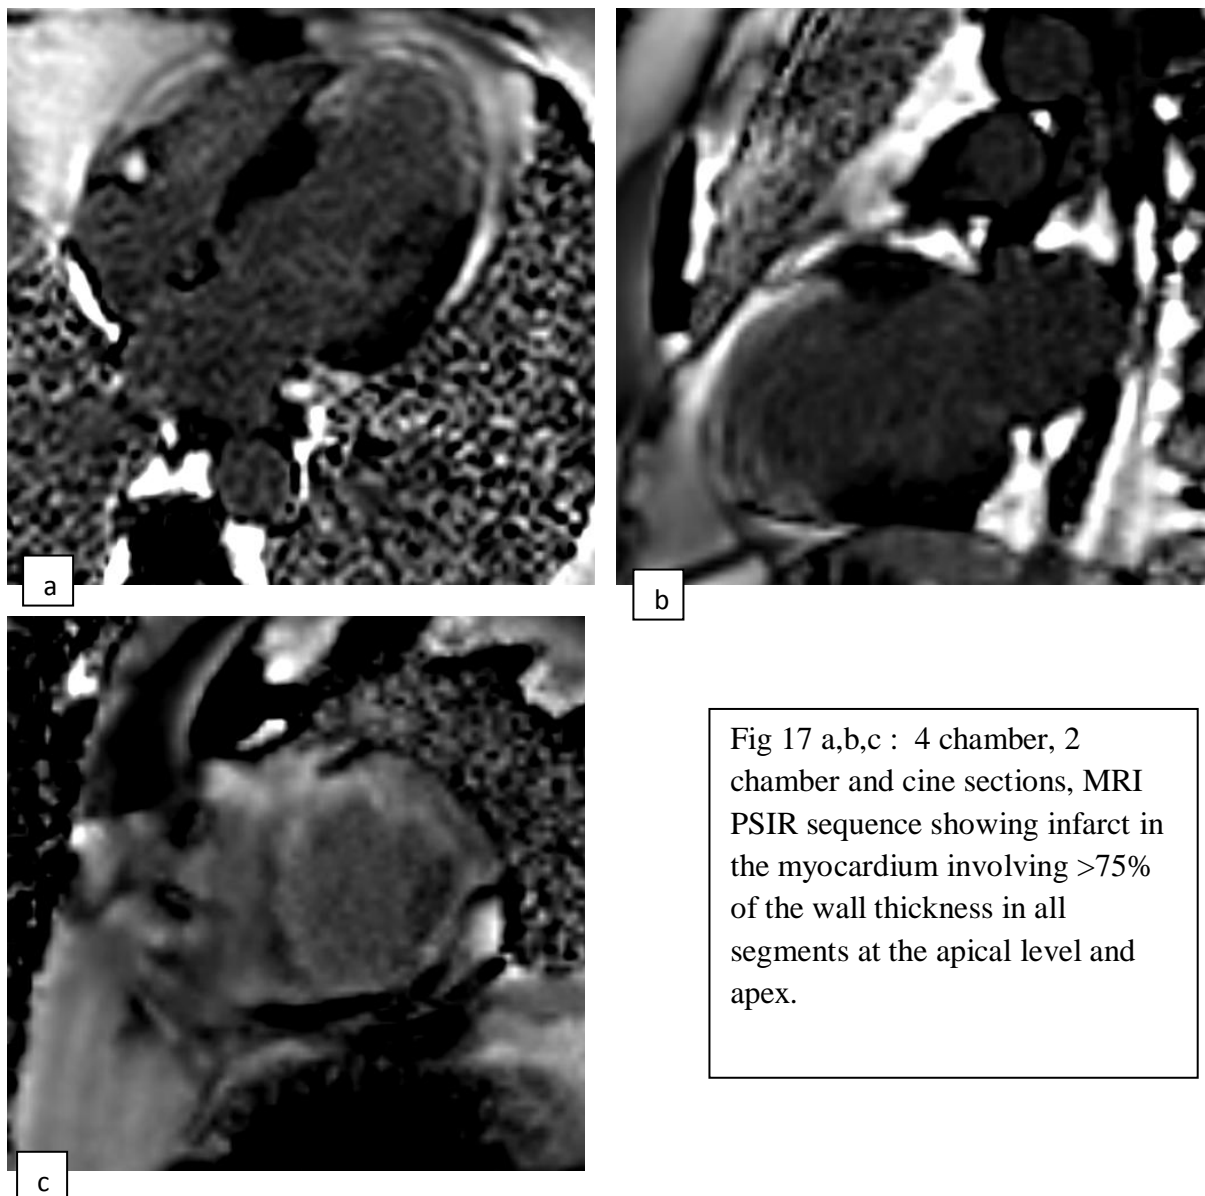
a,b,c : 4 chamber, 2 chamber and cine sections, MRI PSIR sequence showing infarct in the myocardium involving >75% of the wall thickness in all segments at the apical level and apex.
